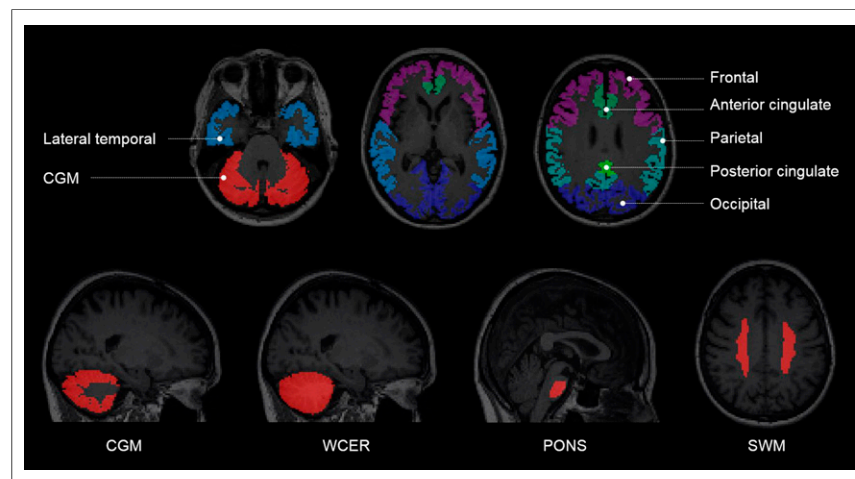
Example of regions of interest generated from segmentation of each subject's MRI.
